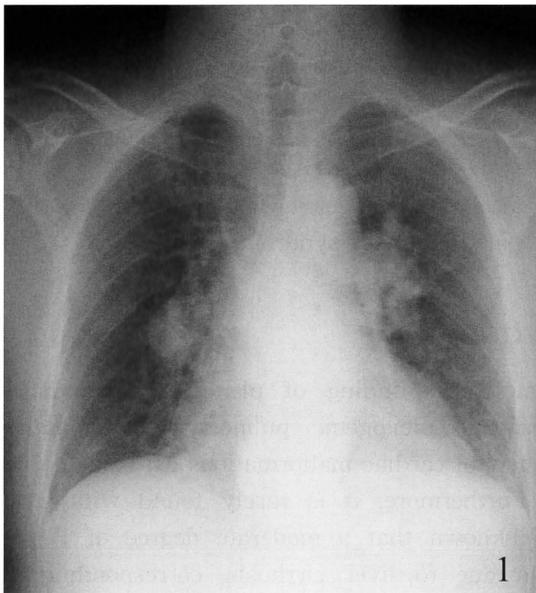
Chest x-ray showed the enlargement of bilateral hilar shadows and elevation of cardio-thorax ratio (CTR).
